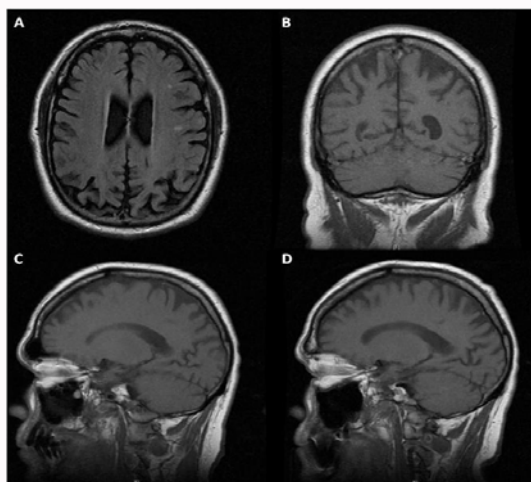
MRI shows atrophy in the parieto-occipital junction bilaterally: (A) Axial T2 FLAIR. (B) Coronal T1 FSE. (C) Sagittal T1 FSE (Left hemisphere). (D) Sagittal T1 FSE (Right hemisphere).
